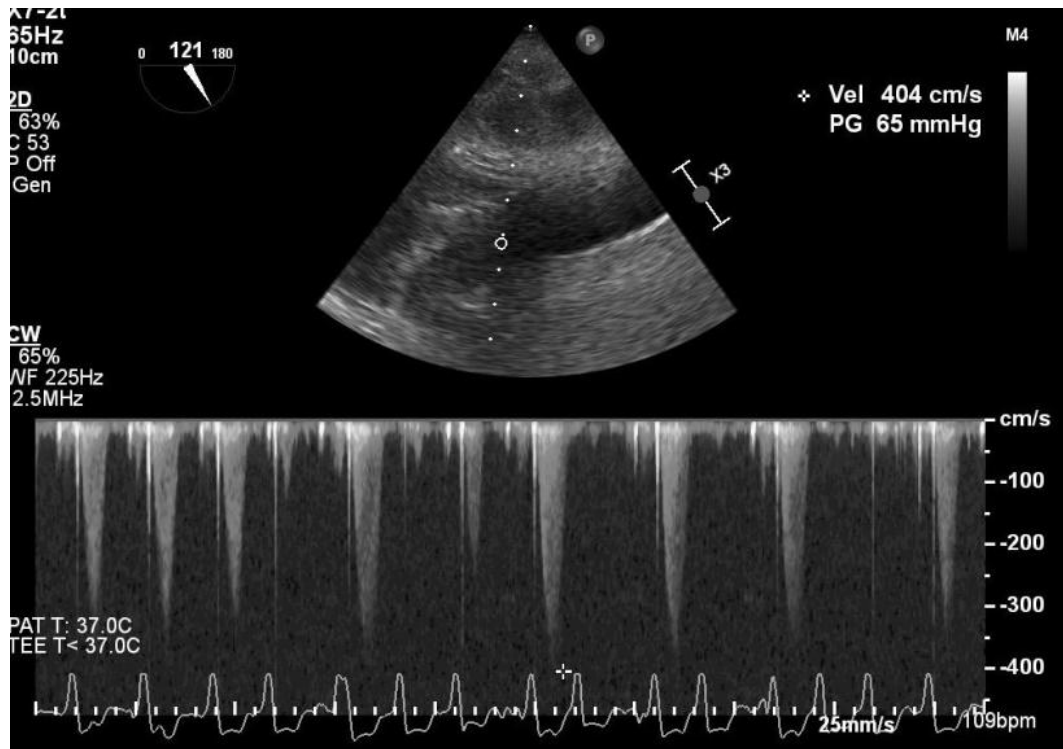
TEE deep transgastric view:continuous flow Doppler shows peak velocity of the flow in the LVOT of 4 m/s
